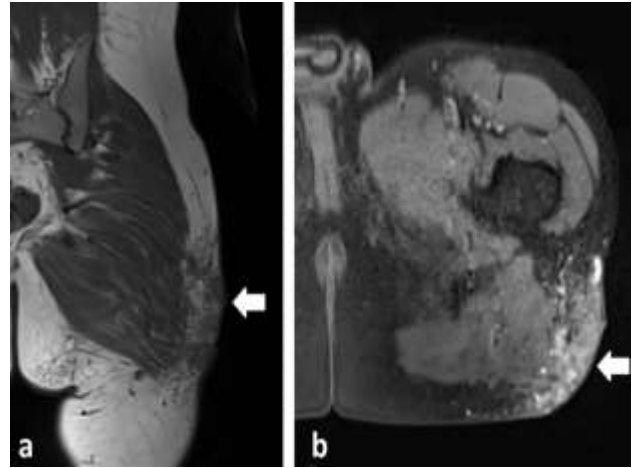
Pre-operative coronal (a) and axial (b) images of the MRI.
